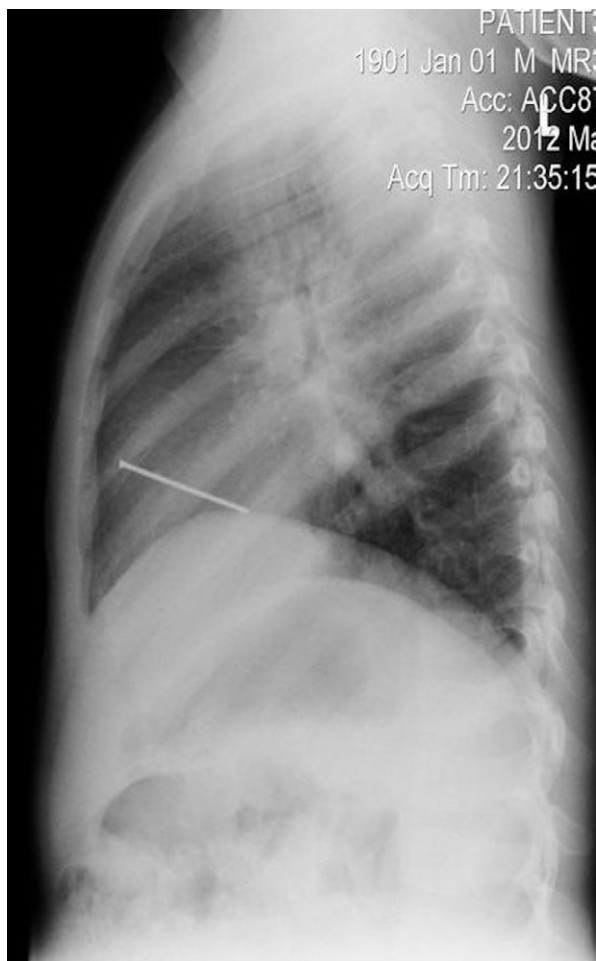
Patient 1. Chest radiograph (lateral view) shows the position of the nail in the left hemithorax, penetrating the heart.
